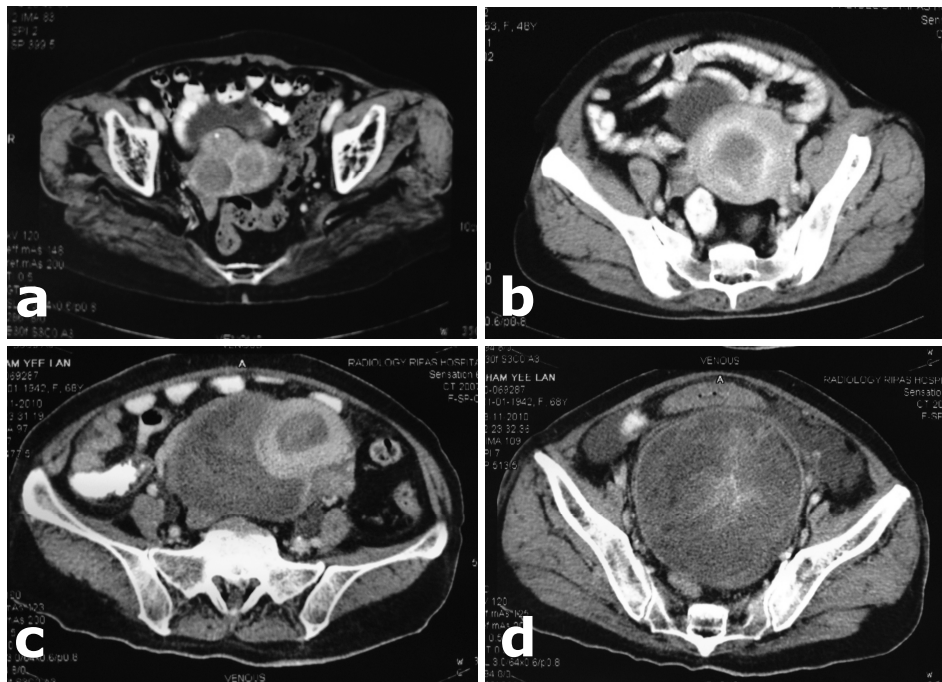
Axial computed tomography (CT) images showing uterine sarcomas of various sizes; a) small sarcoma that resembled uterine fibroids, b) sarcoma with hydrometria, c) sarcoma of moderate size and, d) a large uterine sarcoma.
